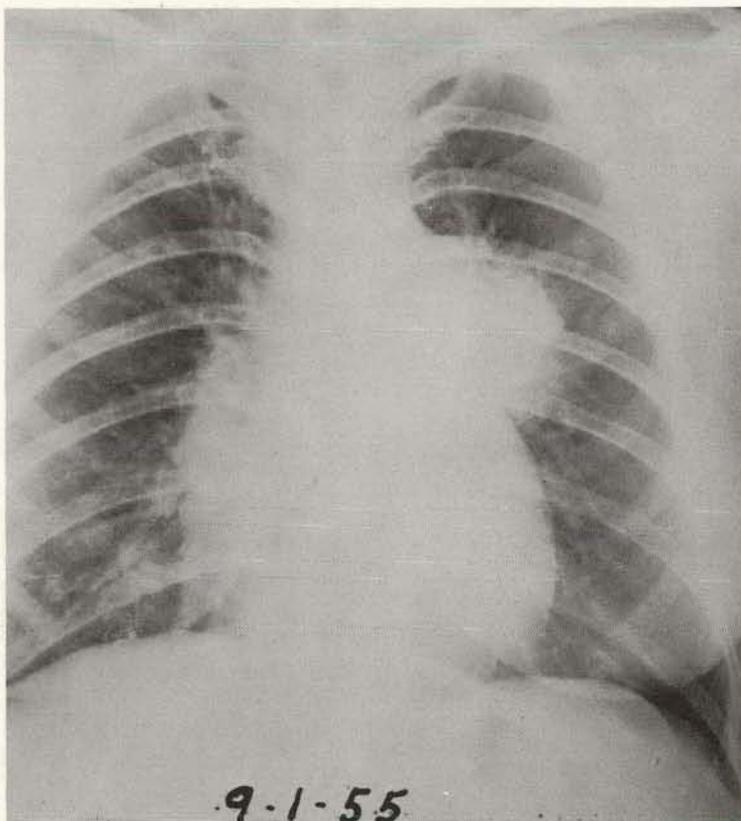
Same patient as shown in Figure 76. Roentgenograph of chest, September 1, 1955. I^{131} uptake was 25% in 6 hrs., chiefly in neck. Desiccated thyroid, 4 grains daily, was begun.
